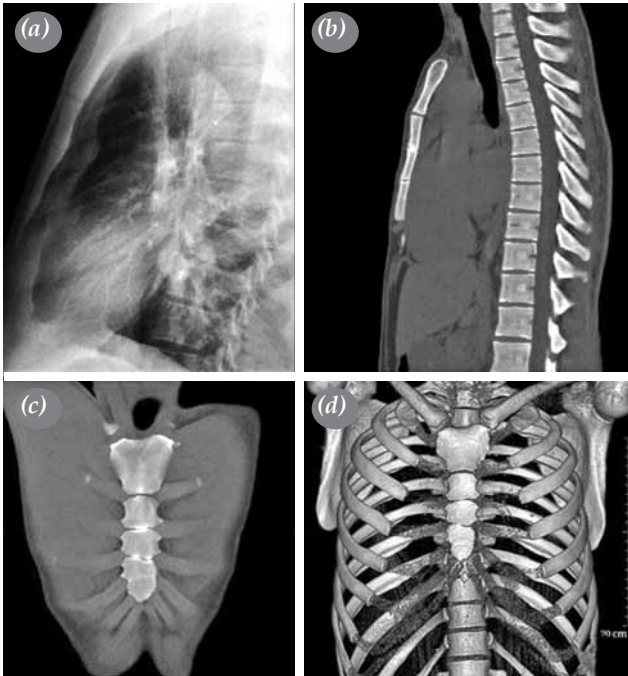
(a) Lateral chest radiograph of first patient demonstrating fissure lines on corpus sternum. (b) Sagittal, (c) coronal (d) and three-dimensional computed tomography images demonstrating transverse fissures dividing corpus sternum to parts.
